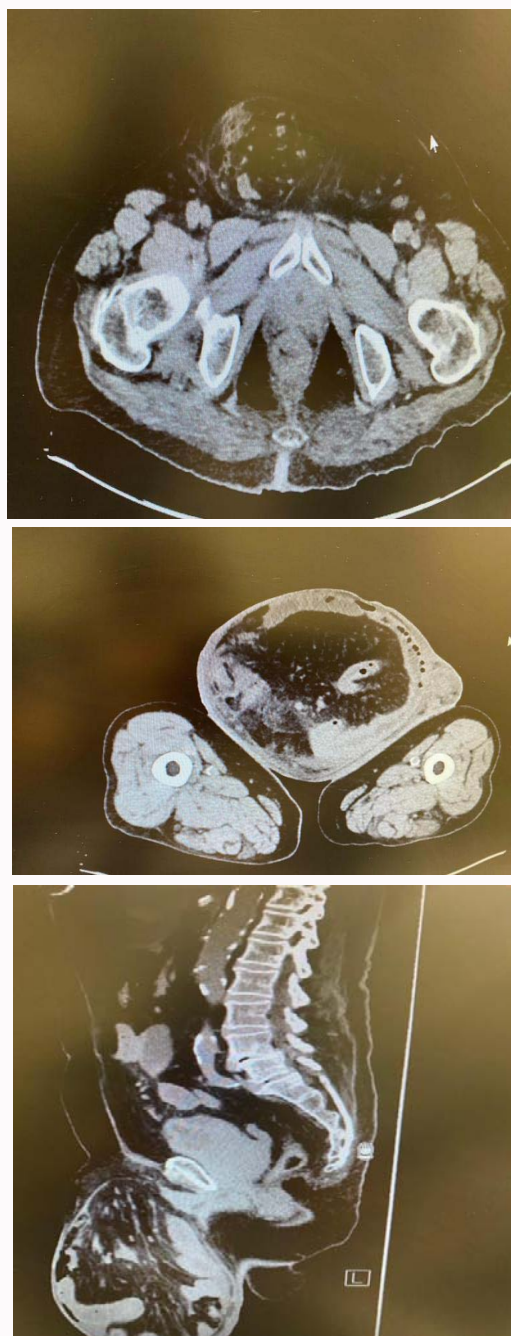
CT scans of hernia sac at multiple levels.
